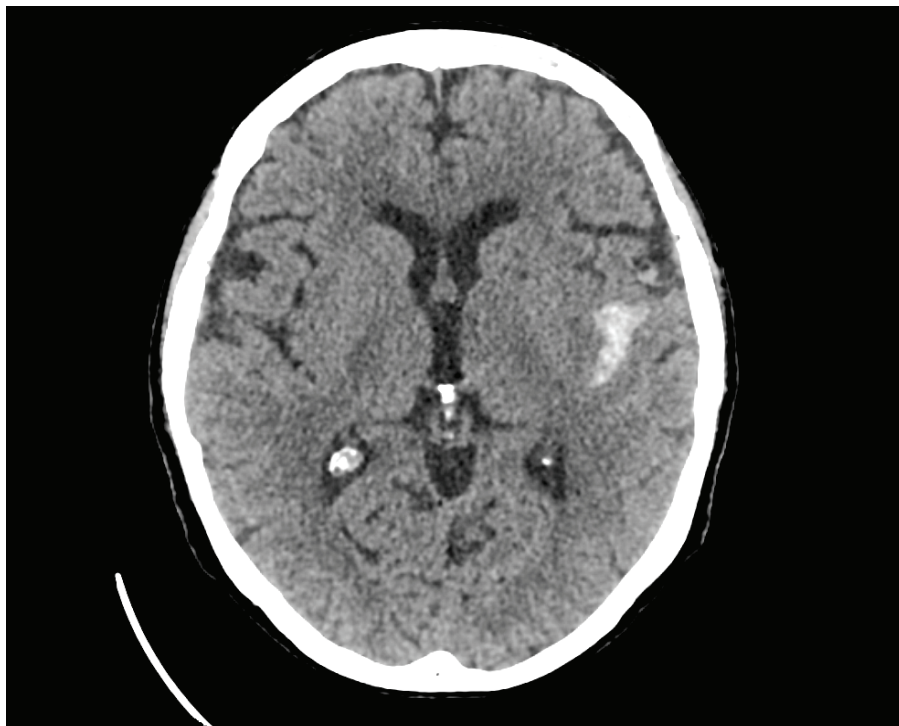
CT scan revealing left sylvian SAE
